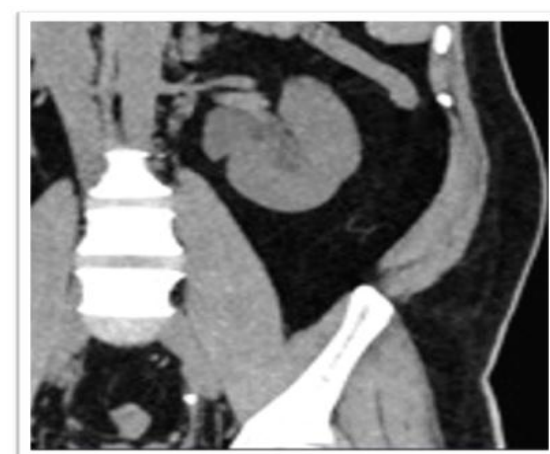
Non-contrast coronal CT image demonstrating a left distal ureteric calculus with upstream hydronephrosis, confirming the cause and level of obstruction.
